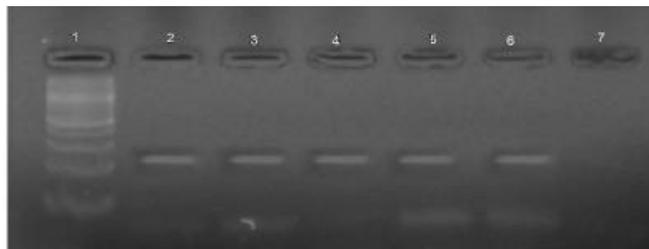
IL-4, Lane 1 DNA ladder 100 bp (fermentas). Lane 2 normal allele band at 215 bp, lane 3 normal allele band at 215 bp this patient (CT) polymorphism. Lane 6 normal allele band at 215 bp and lane 7 mutant allele no band at 215 bp this polymorphism (CC).
